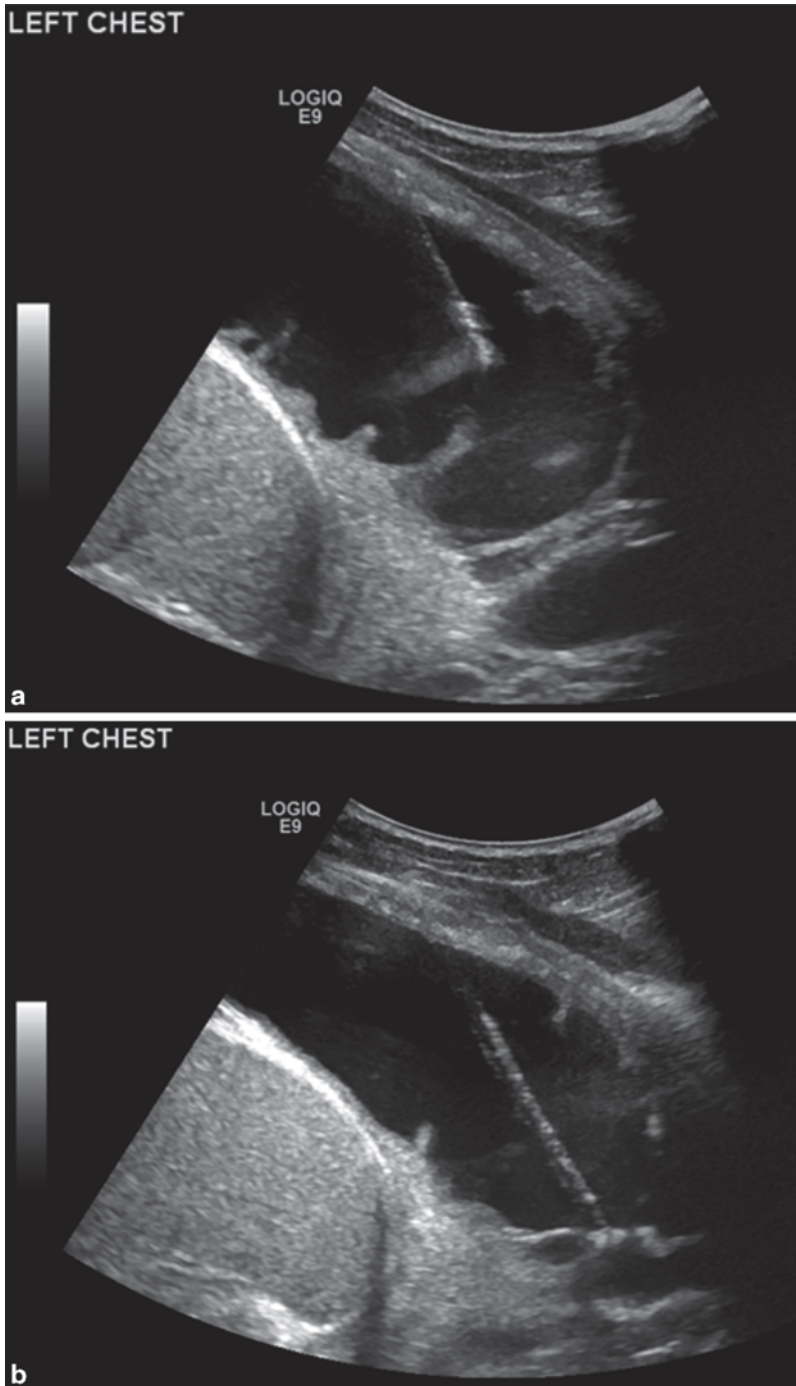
Pleural empyema. Ultrasound demonstrates complex fluid collection with debris, loculation, and septations
